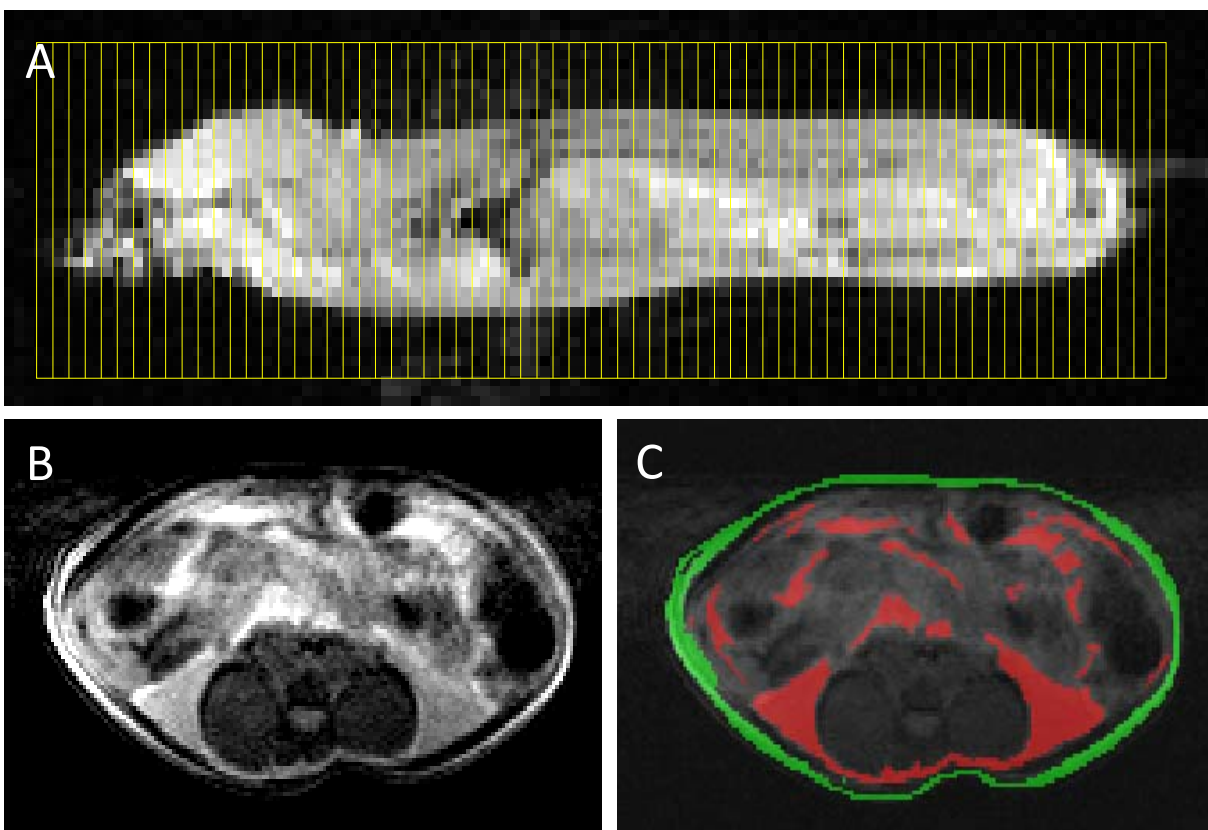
Planning of the axial MR images across the body.
